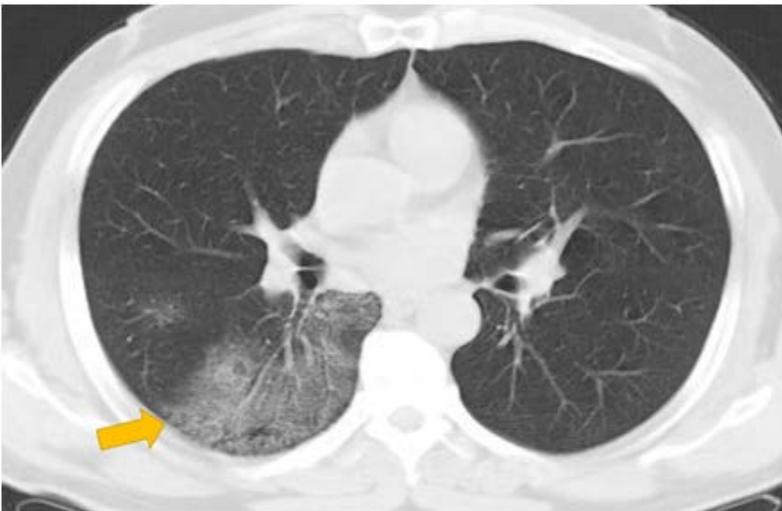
Crazy paving pattern in a 66-year-old man with COVID-19. Axial chest CT scan shows ground-glass density superimposed with interlobular septal thickening (yellow arrow), consistent with crazy-paving pattern.
